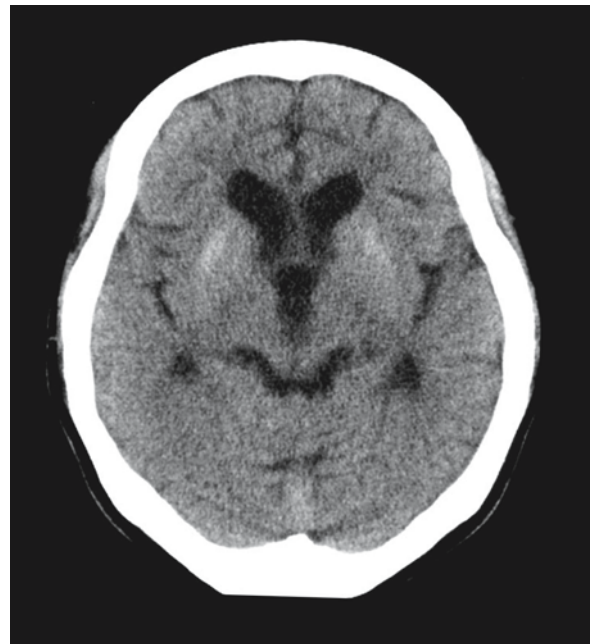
Female PLOSL patient, 38 years old. The CT scan demonstrates the calcium deposits in the basal ganglia. Courtesy of Dr. Y. Ueki, Dr. N. Kohara, Dr. H. Fukuyama, and Dr. Y. Miki, Departments of Neurology and Brain Pathophysiology, Faculty of Medicine, Kyoto University, Kyoto, Japan
